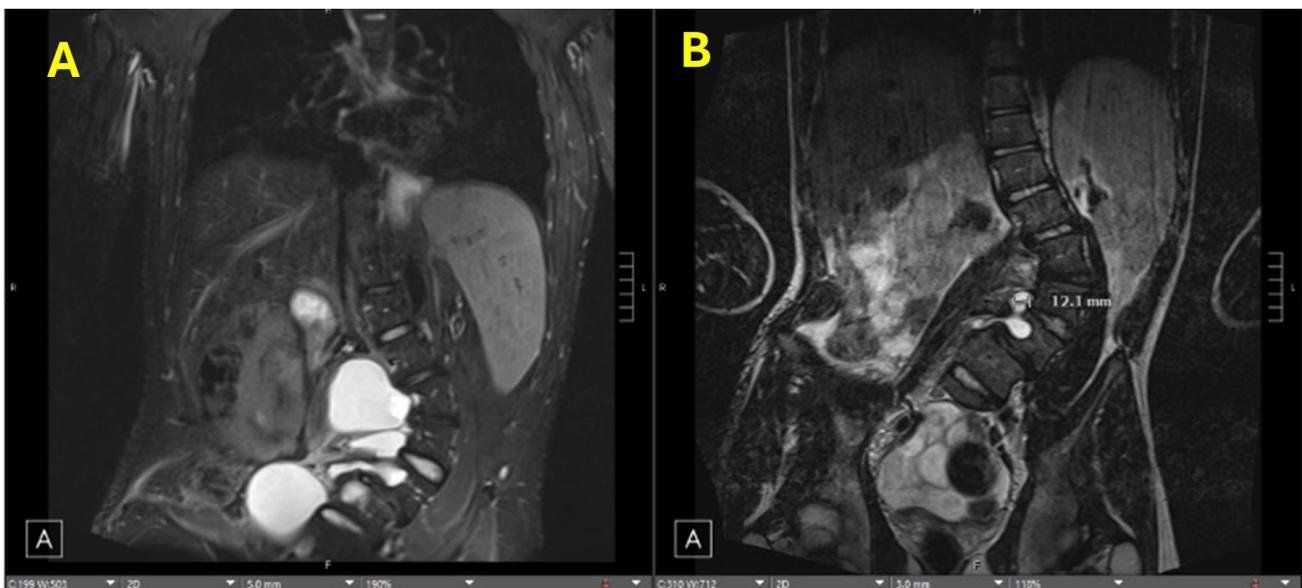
Thorac-abdominal magnetic resonance imaging. (A) 2024 coronal T1-weighted MRI with contrast that depicts lumbar levoscoliosis and marked progression of lumbar dural ectasia causing a severe mass effect to adjacent structures, compared to the (B) coronal T1-weighted contrast MRI of 2008.
